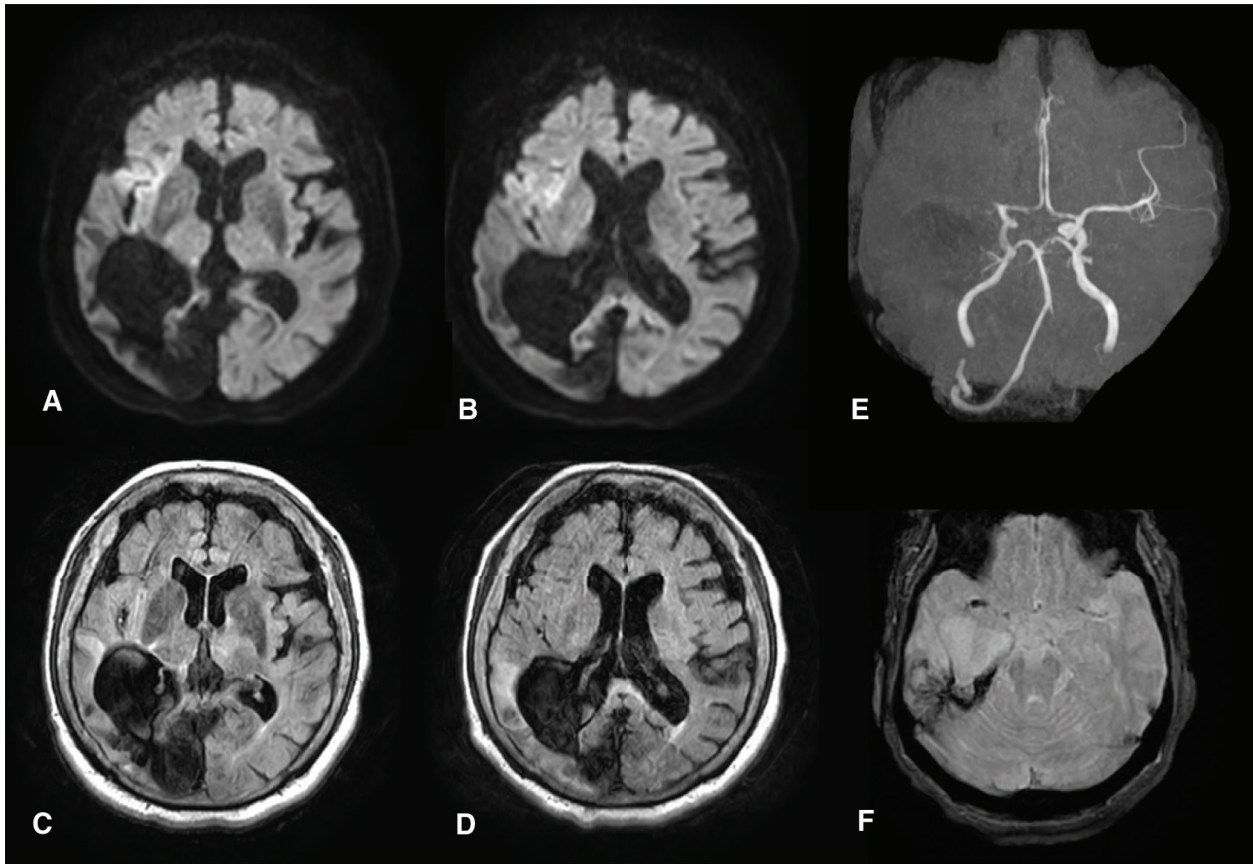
(A and B) The pretreatment DWI-ASPECTS was 7. (C and D) Pretreatment FLAIR imaging showed old cerebral infarction involving the right temporal to occipital lobes. (E) On pretreatment MRA, neither the right middle cerebral nor left vertebral arteries were visualized. (F) T2-weighted imaging revealed an SVS in the right MCA. ASPECTS: Alberta Stroke Program Early CT Score; DWI: diffusion-weighted imaging; MCA: middle cerebral artery; SVS: susceptibility vessel sign
